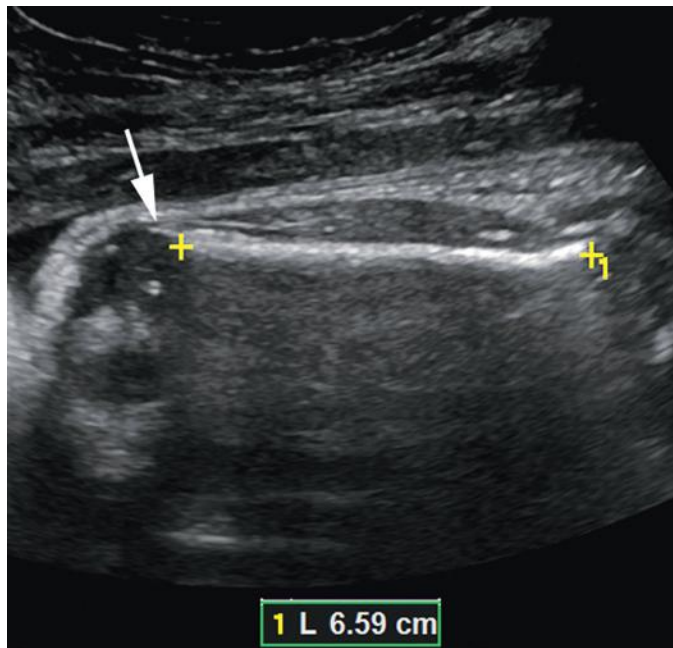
Femur length measurement. Sonogram of femur with ossified diaphysis measured (*calipers*). The linear projection from the diaphysis of the femoral epiphysis (*arrow*) is not included in the measurement.
